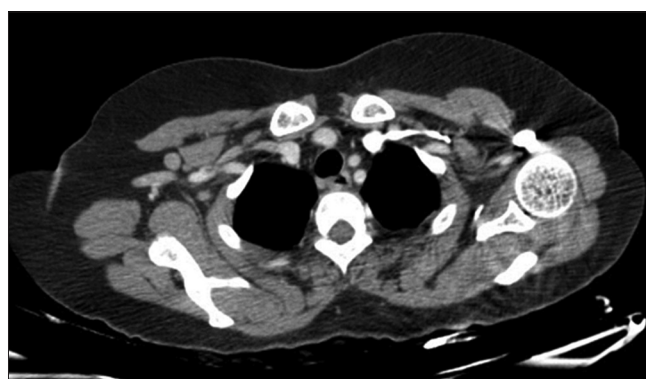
CT images show well-defined rounded right axillary lymph nodes
